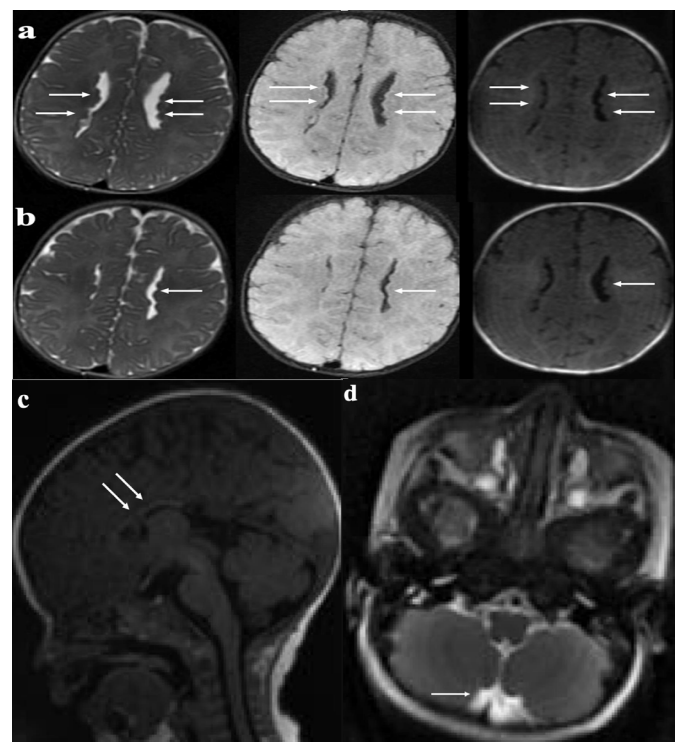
The axial (a, b) T2-weighted, FLAIR, and T1-weighted turbo spin-echo (TSE) imaging reveals multiple nodules of heterotopia (arrows) gray matter remain isointense with the cortical gray matter lining along the body of lateral ventricles. Additionally, the sagittal 3D MPR image (c) demonstrates that a thinning of the corpus callosum according to age. Furthermore, there is a small focal cerebrospinal fluid (CSF) enlargement (d) at the posterior fossa
